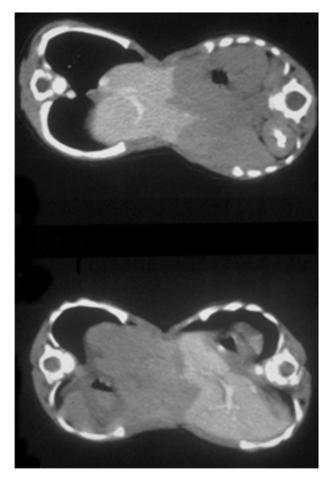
CT scan with contrast to show line of liver union.
